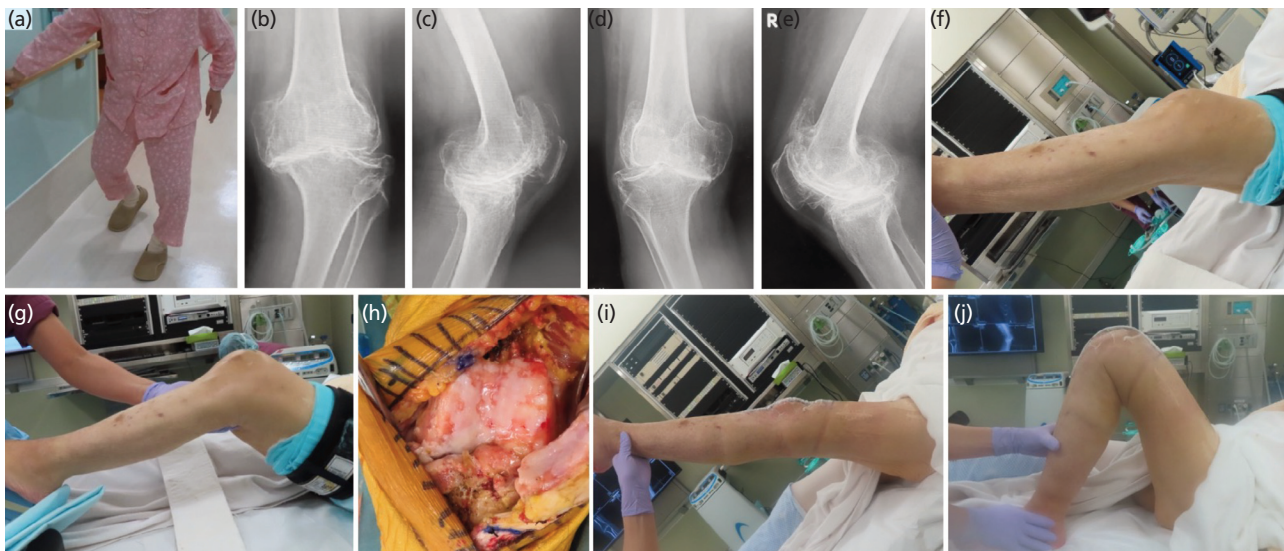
Pre-operative knee joint ROM 15° – 35° under general anaesthesia. Post-operative knee joint ROM 5° – 125° under general anaesthesia. (a) Walking condition immediately before surgery. (b) Pre-operative left knee radiograph front view. (c) Pre-operative left knee radiograph lateral view. (d) Pre-operative right knee radiograph front view. (e) Pre-operative right knee radiograph lateral view. (f) Pre-operative left knee extension under general anaesthesia. (g) Pre-operative left knee flexion under general anaesthesia. (h) Left knee joint under general anaesthesia. (i) Post-operative left knee extension under general anaesthesia. (j) Post-operative left knee flexion under general anaesthesia.
